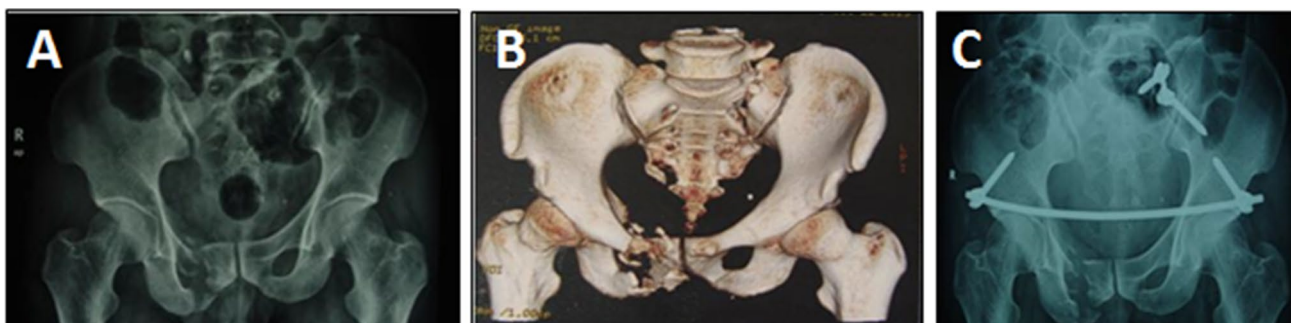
A 37-year-old male patient with traffic accident. a A vertically and rotationally unstable pelvic fracture with sacroiliac joint dislocation (Tile C type). b 3D computed tomography scans and c after stabilization with an anterior INFIX in combination with a posterior S1 pediculoiliac screw fixation
